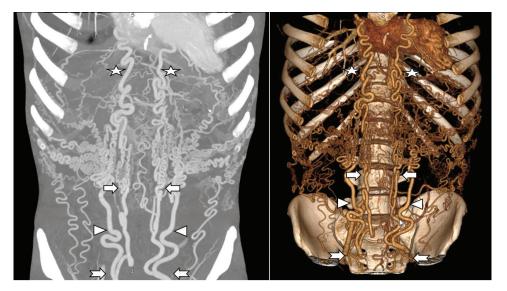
Computed tomography angiography MIP and VRT images showing welldeveloped Winslow pathway collaterals bilaterally that start as enlarged internal thoracic arteries (stars) in the thorax and continue as multiple vascular channels that anastomose the superior and inferior epigastric arteries (arrows and arrowheads respectively) and finally drain into the external iliac arteries (notched arrows).
